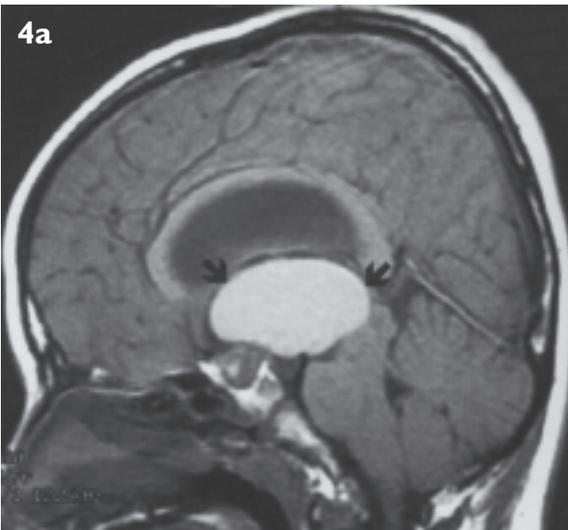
MR images of child with craniopharyngioma. (a) Unenhanced sagittal T1-weighted MR image shows suprasellar mass with intrasellar extension. The cystic component of the mass (arrows) is hyperintense. (b) Unenhanced axial T1-weighted MR image shows solid component (arrows) of mass, which is heterogeneously intense. Note dilatation of temporal horns. (c) Corresponding unenhanced axial T2-weighted image shows slightly hyperdense mass. The small hypointense area (arrow) within mass represents calcification. (d) Enhanced sagittal T1-weighted MR image shows enhancement of solid component of mass (black arrow) and enhancement of wall of the cyst (white arrow).
